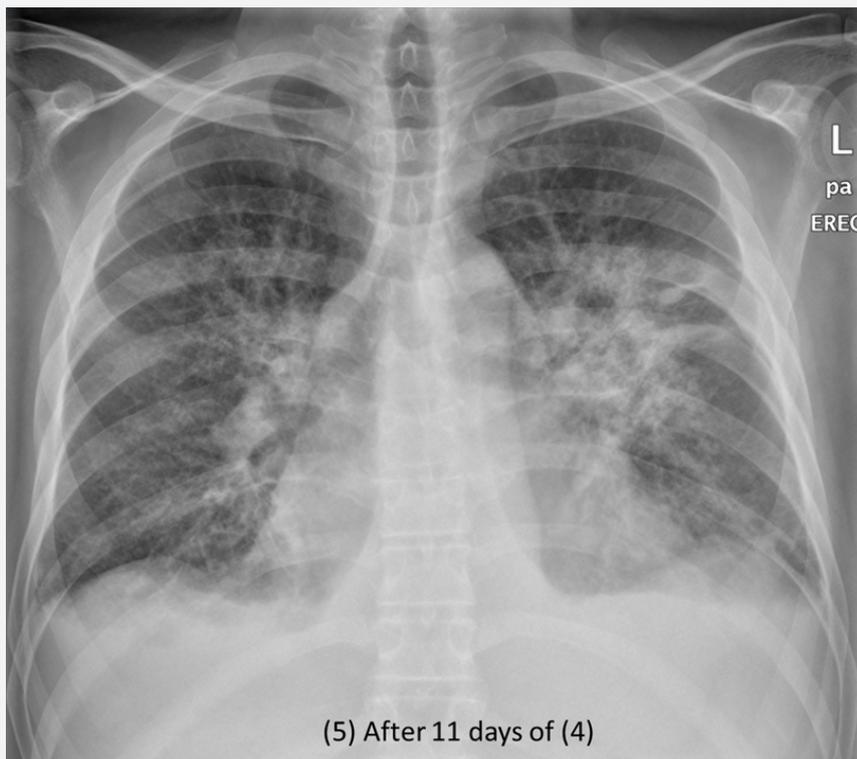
X-ray chest portable semi sitting projection: Interval improvement in previously seen bilateral perihilar airspace disease, more improvement on right side as well as improvement in minimal right pleural effusion and bilateral basal atelectasis. Findings are keeping with interval improvement in changes of pulmonary edema.
